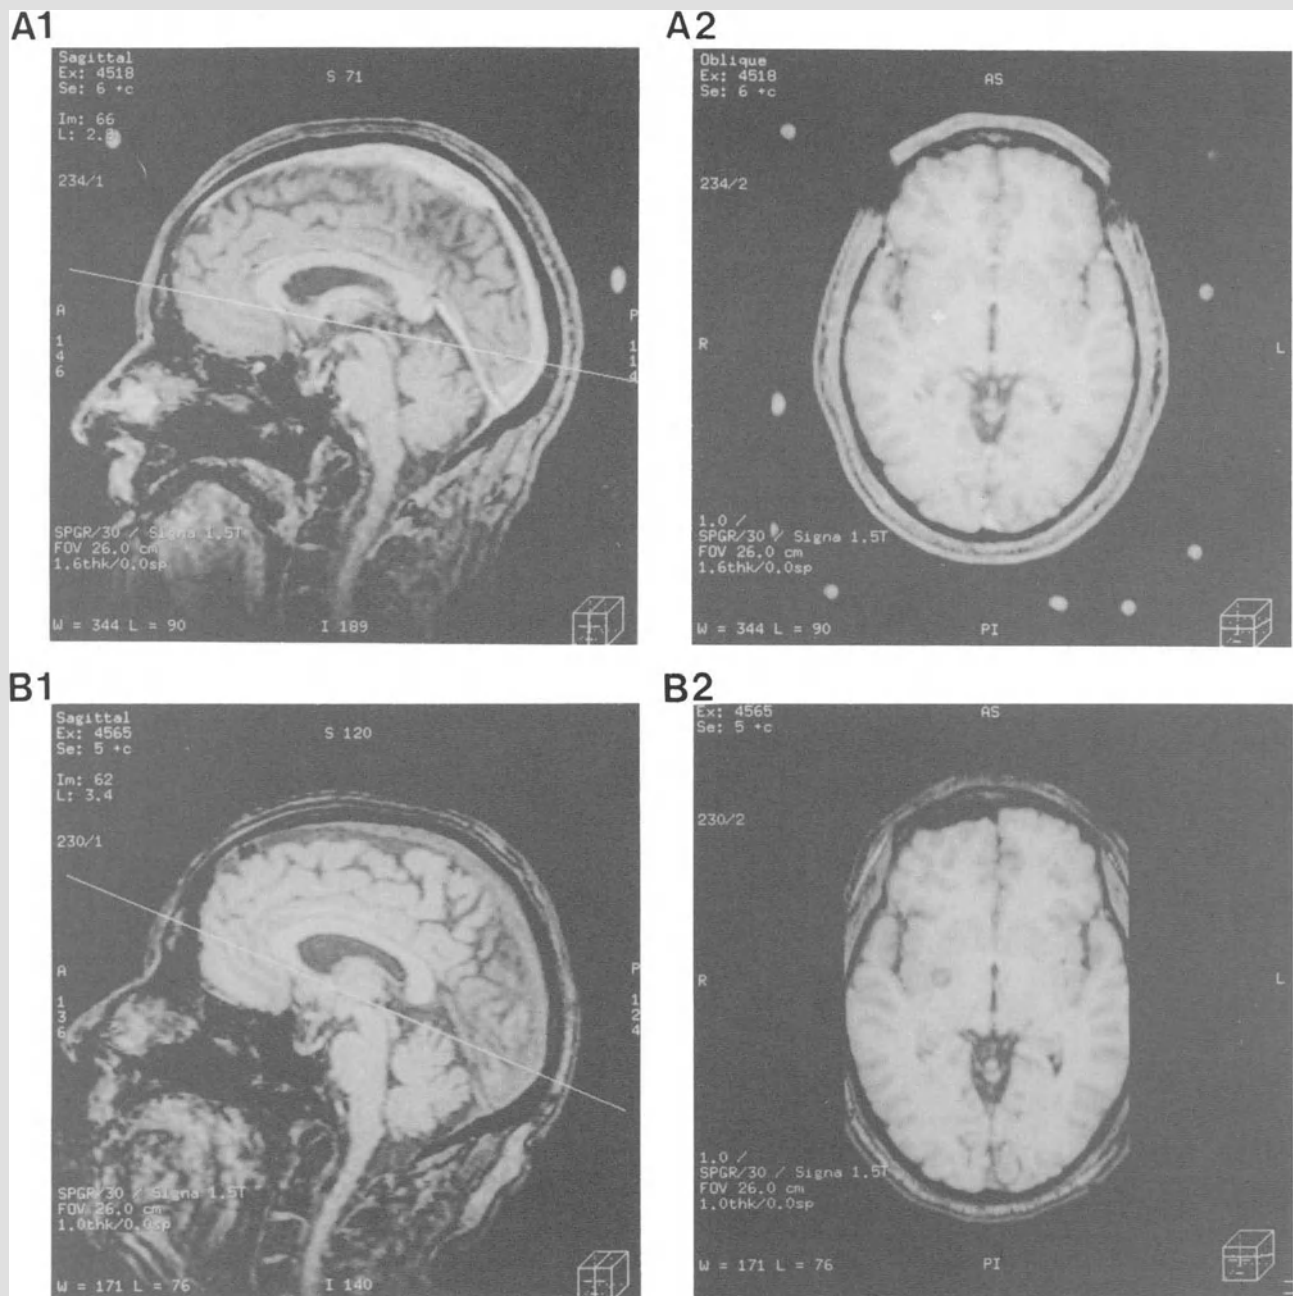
(A) Pre-operative MRI. One axial slice through intercommissural plane of 60 slice volumetric study. Note target selection. (B) Post-pallidotomy MRI, same slice of volumetric study. (C) Difference (subtraction) image (A2-B2) (see p. 34). Lesion seen at superior extent of slice level readily confirmed, i.e. *intercommissural plane*
